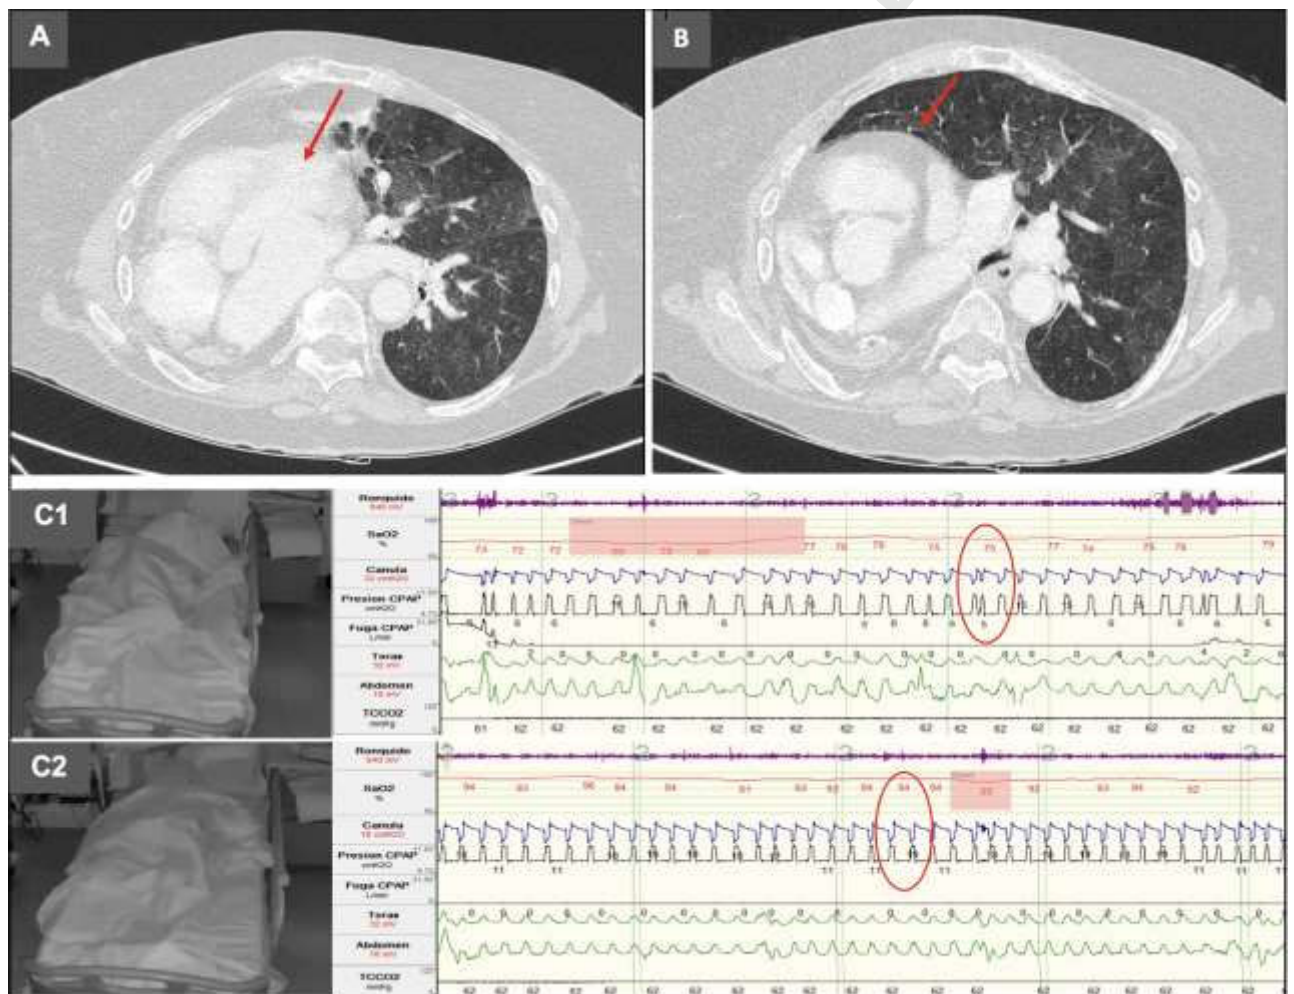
(A) Chest computed tomography demonstrating congenital dextrocardia (arrow). (B) Congenital pulmonary hypoplasia (arrow). (C1) NIV titration in the left lateral decubitus position showing ventilatory asynchronies and hypocapnia (oval). (C2) NIV titration in the right lateral decubitus position with resolution of asynchronies and improved oxygen saturation (oval).
